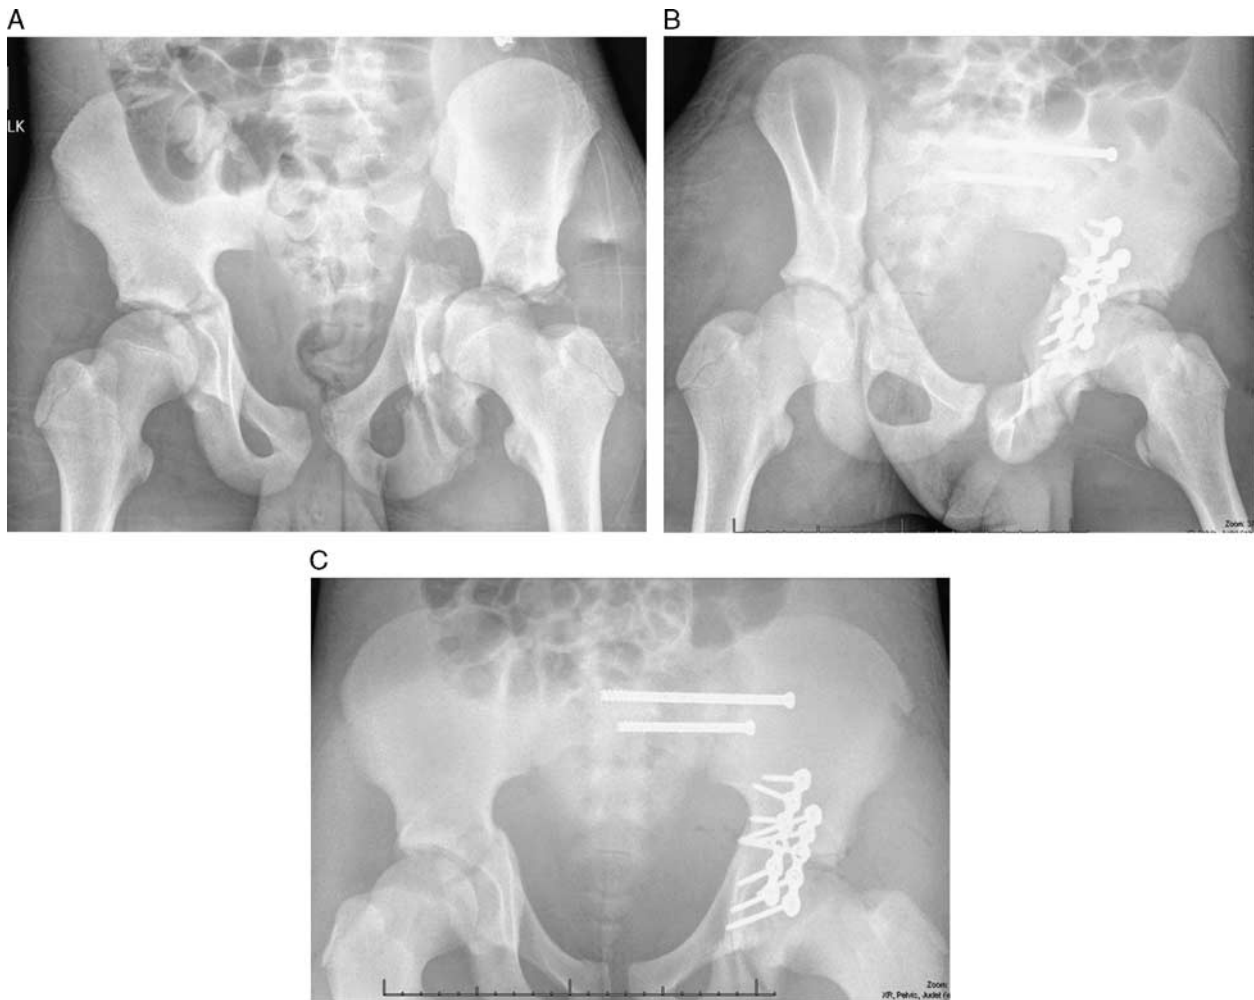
Subject 625—complex pelvic/acetabular injury. A, AP pelvic radiograph demonstrating bilateral acetabular fractures and left sacroiliac joint dislocation in a 13-year-old motocross participant. B and C, AP and iliac oblique radiograph after open reduction and internal fixation of the left acetabulum and sacroiliac joint.
